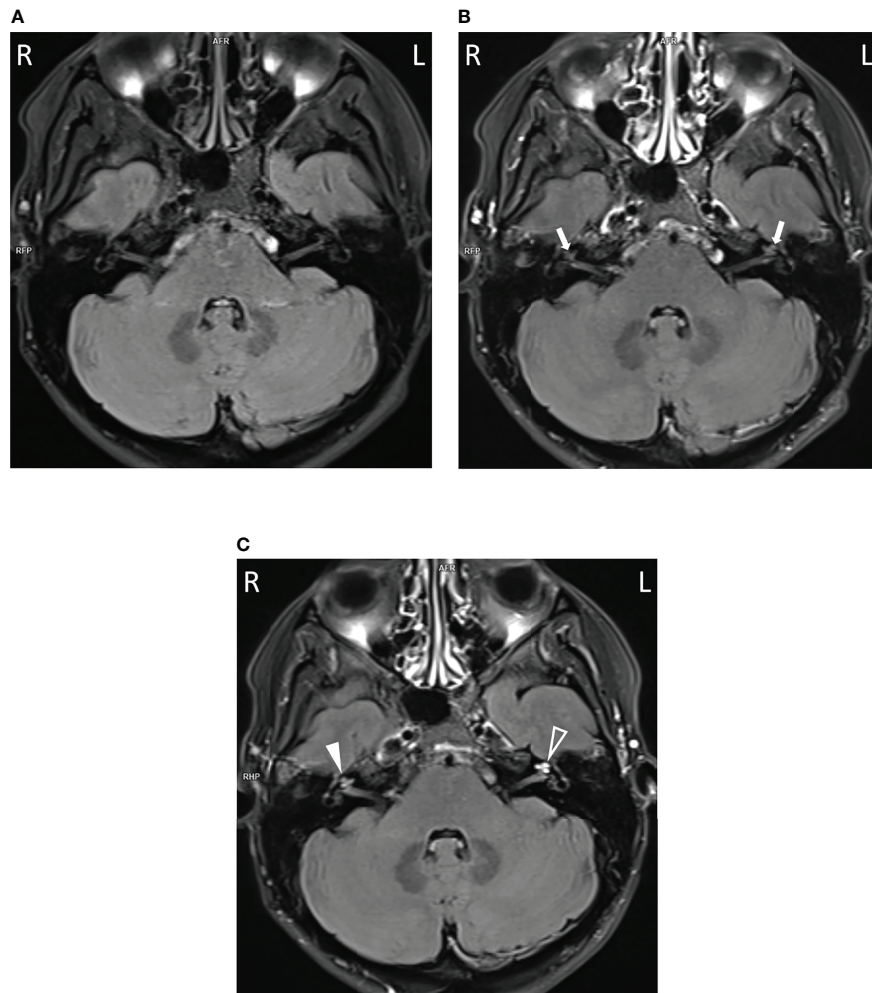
Cochlear enhancement on FLAIR images in the proband. In comparison to non-contrast image (A), mild cochlear enhancement (arrows) is seen on the early FLAIR image (B). On the late FLAIR image (C), substantial enhancement (more pronounced on the left, empty arrowhead) is observed in both cochleas (arrowheads).
